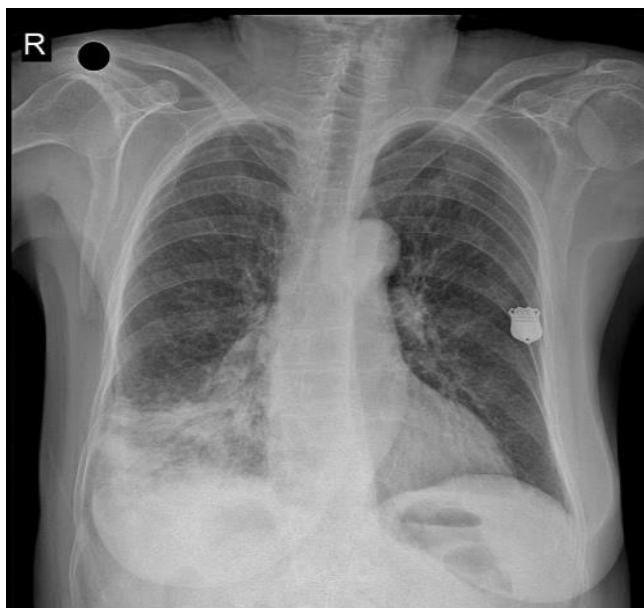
A homogeneous density observed in the lower zone of the right lung on Chest X-ray
